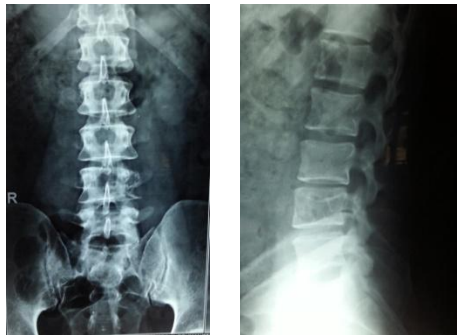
xray shows lytic lesion
